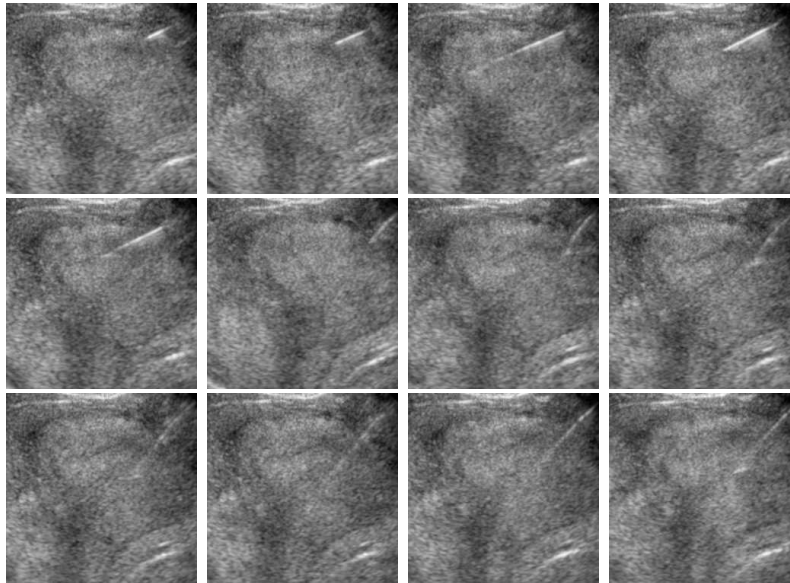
Images above are 12 sample frames among total 100 frames of ultrasound images during Phase II.
